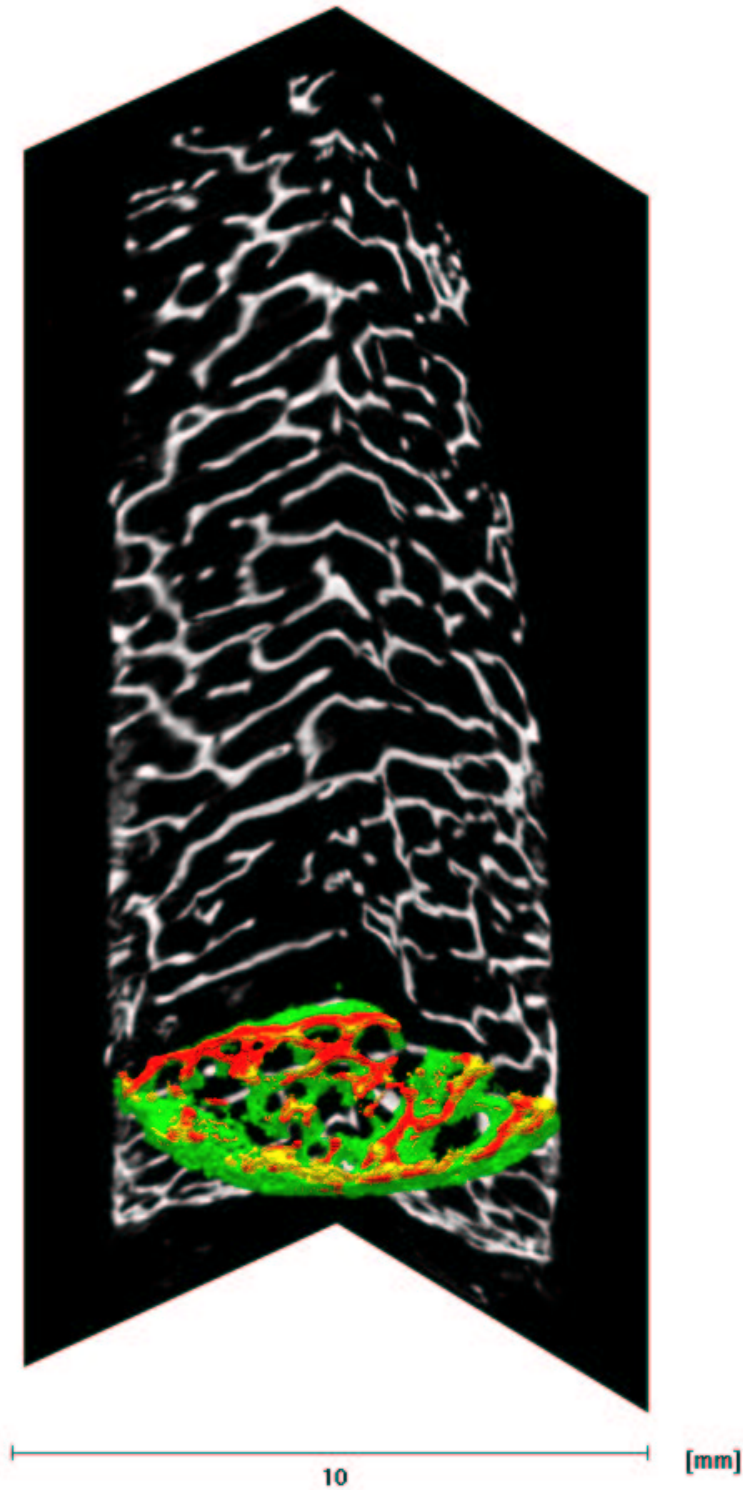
Tibia bone biopsy data set acquired by  $\mu$ -CT. Sagittal and coronal plane reconstructions are shown in gray-scale. A transaxial symbol-encoded slice is seen in the lower part. The thin cortical tibia bone from the medial side of the tibia is at the bottom of the image.
